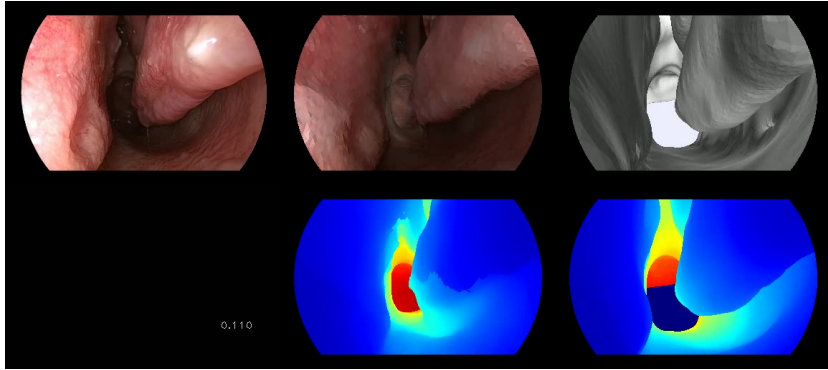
Example of color and depth renderings of dense reconstruction from estimated camera trajectory (middle column) and CT renderings from ground-truth trajectory (right column) with the corresponding endoscope image shown on the left.
